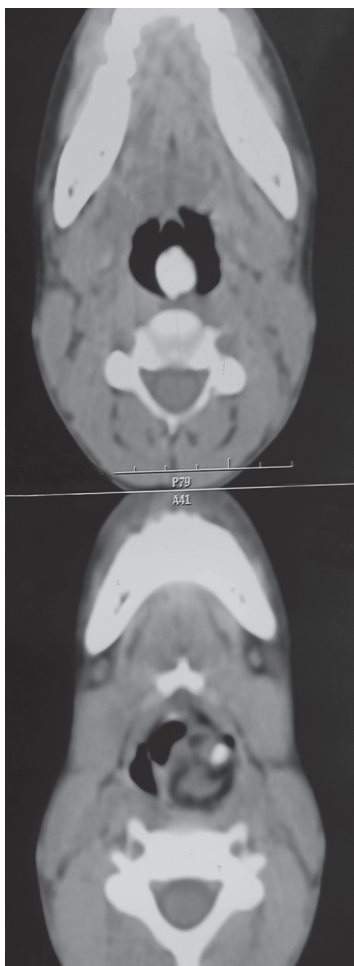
Contrast-enhanced computed tomography (CECT) showing heterogeneous lesion with an area of dense calcification and fat density arising from the left posterolateral wall of the hypopharynx
